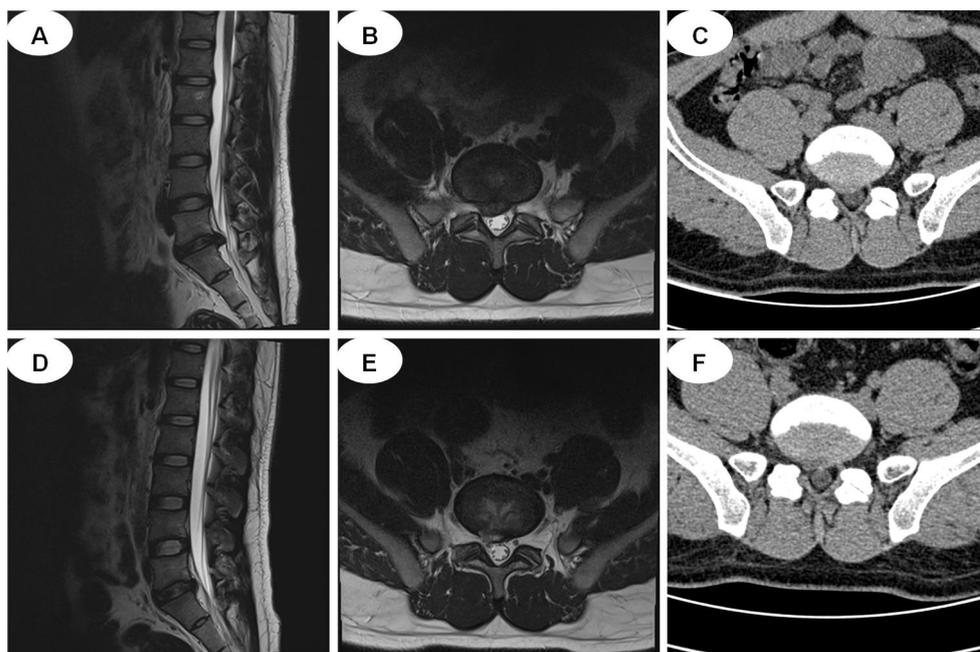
CT and MRI images. (A-C) MRI and CT show L5-S1 discal hernia before surgery; (D-F) MRI and CT show the herniated nucleus pulposus is removed after surgery. CT, computed tomography; MRI, magnetic resonance imaging.
